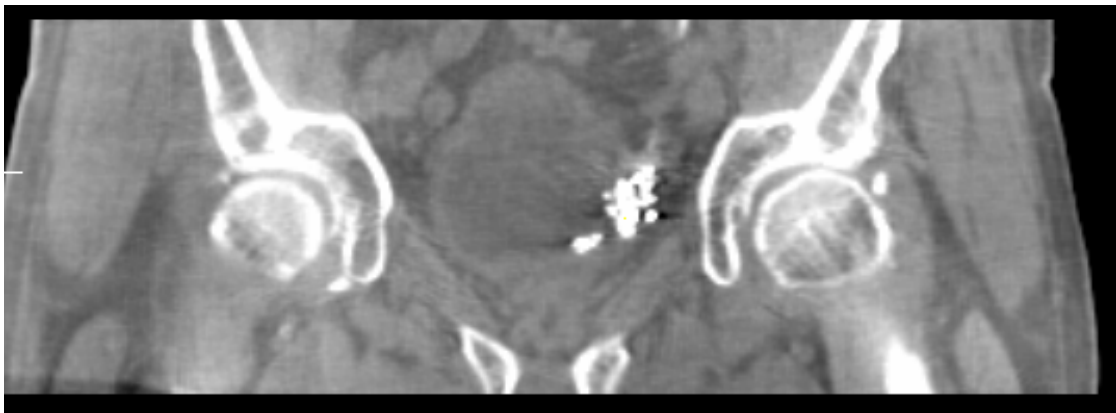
Coronal view of a CBCT image using preset Prostate M10. Bladder of the patient can be seen in the middle of the image. Lipiodol is visible in the image as light area on the lateral wall of the bladder.
